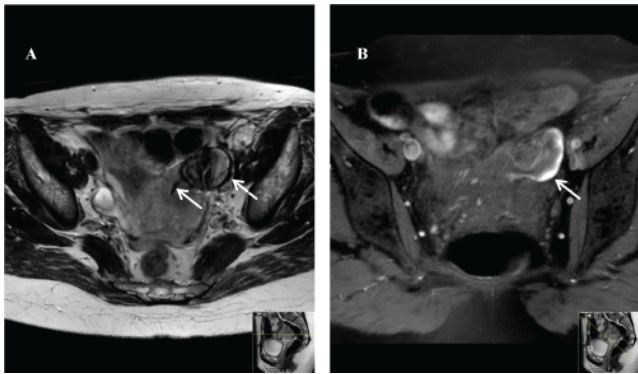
A) MRI (T2 WI) of the lower abdomen showing subserosal cavity with hypointense lining (dotted arrow) indicating blood products, continuing into the uterine incision (straight arrow). B) MRI (T1 WI, fat sat) of the lower abdomen showing subserosal cavity with hyperintense lining (straight arrow) indicating the presence of hemosiderine.
